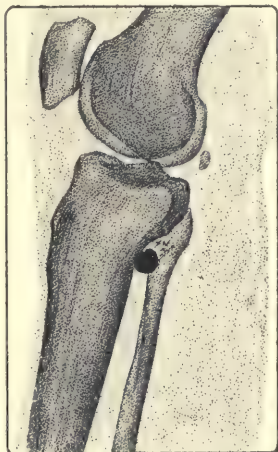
Radiograph of the right leg seen from inner side. The small oval shadow the size of a pea which we see behind the shadow of the femoral condyles corresponds with the sesamoid of the knee. Seen at the upper extremity of the interosseous space there is a shrapnel bullet which must however have come into contact with the bone to judge by the few metal particles which have become detached from it. (Compare also Figs. 1 and 2 of Plate I.)
